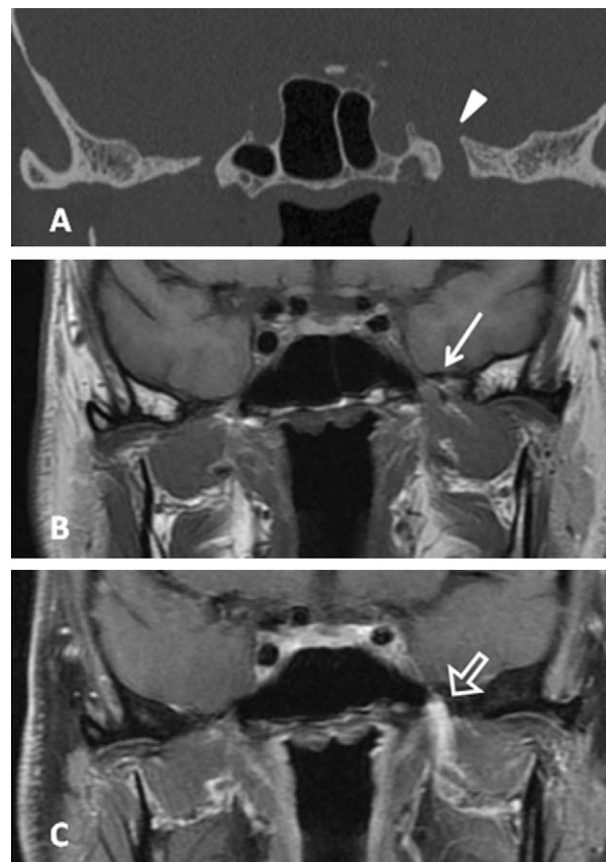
Preoperative computerized tomography scan (A) showing in a coronal view the enlarged foramen ovale (arrow head) by the tumor. Coronal view of T1 weighted magnetic resonance imaging study ((B) without contrast and (C) with contrast) showing a hypodense tumor (white arrow) and a tumor enhancement (open arrow).
